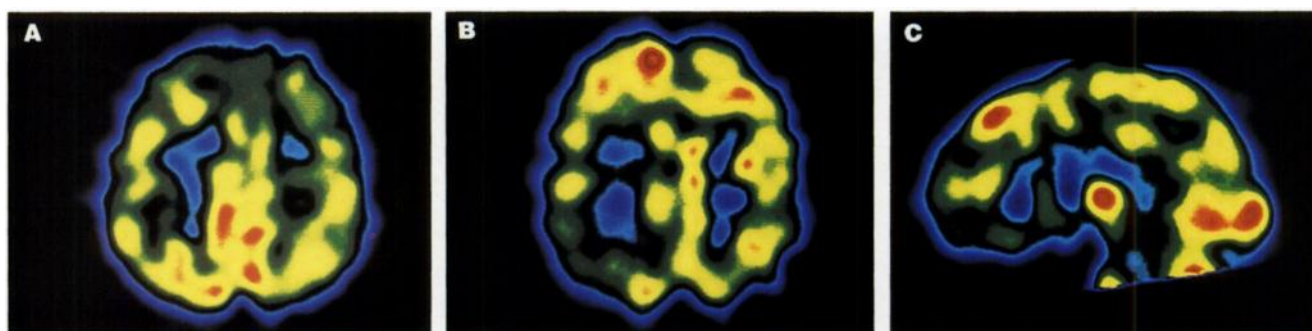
Interictal (A) and ictal (B, C) perfusion pattern in a 34-yr-old man with a suspected EEG focus in the right frontal lobe and normal MRI findings (Patient 4). The interictal study (A, transaxial slice) shows a mild hypoperfusion of both frontal lobes, more pronounced on the right side. The ictal study reveals a circumscribed increased tracer uptake in the right frontal lobe (B = transaxial slice; C = sagittal slice).
